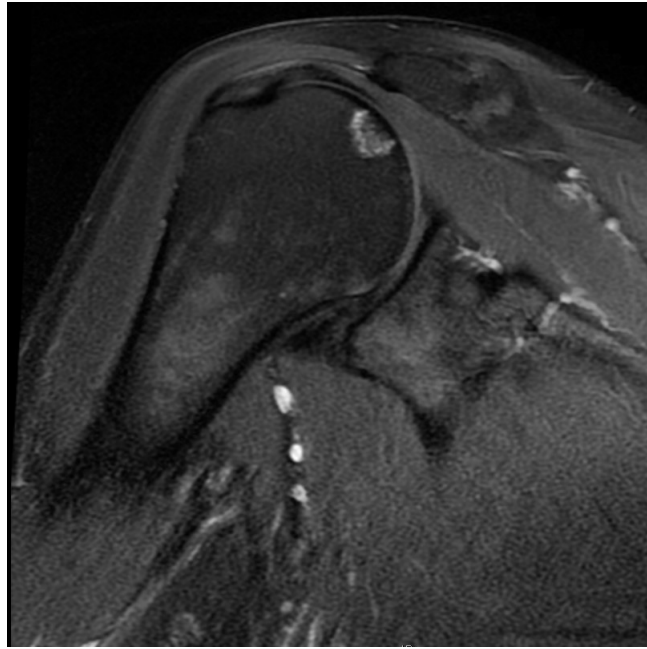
The MRI of the right humeral head . There were two foci with low T1 signal affecting the central superior portions of the head, the larger one measuring approximately 10 mm in diameter
